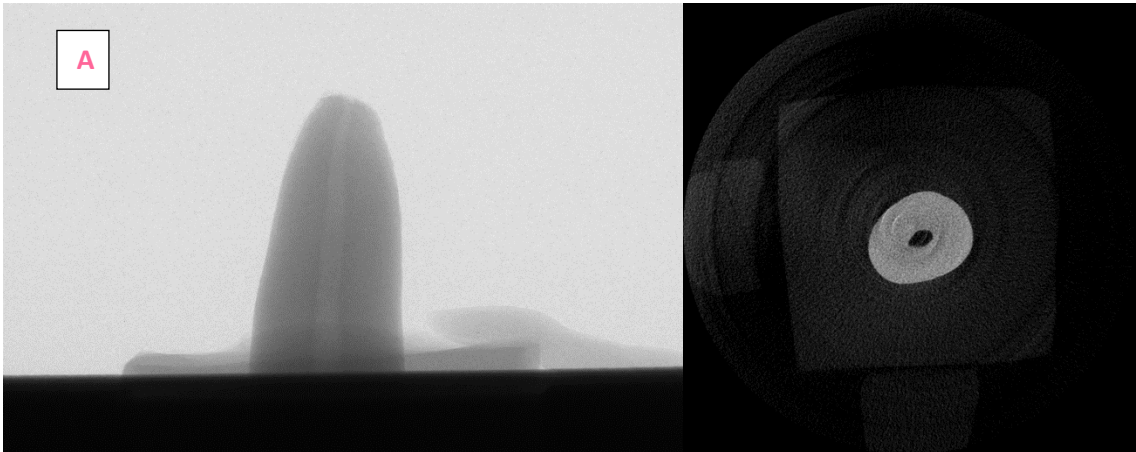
Skyscan CT Analyzer software used for measurement of the canal volume
